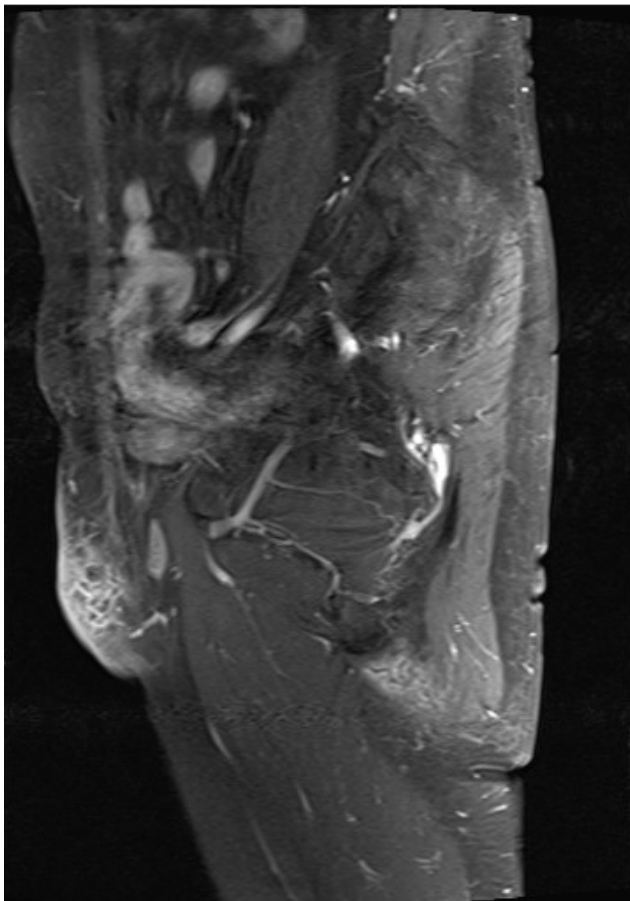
A contrast-enhanced T2-weighted magnetic resonance image with fat saturation shows an enhancing lesion in the subcutaneous layer of the suprapubic area.
